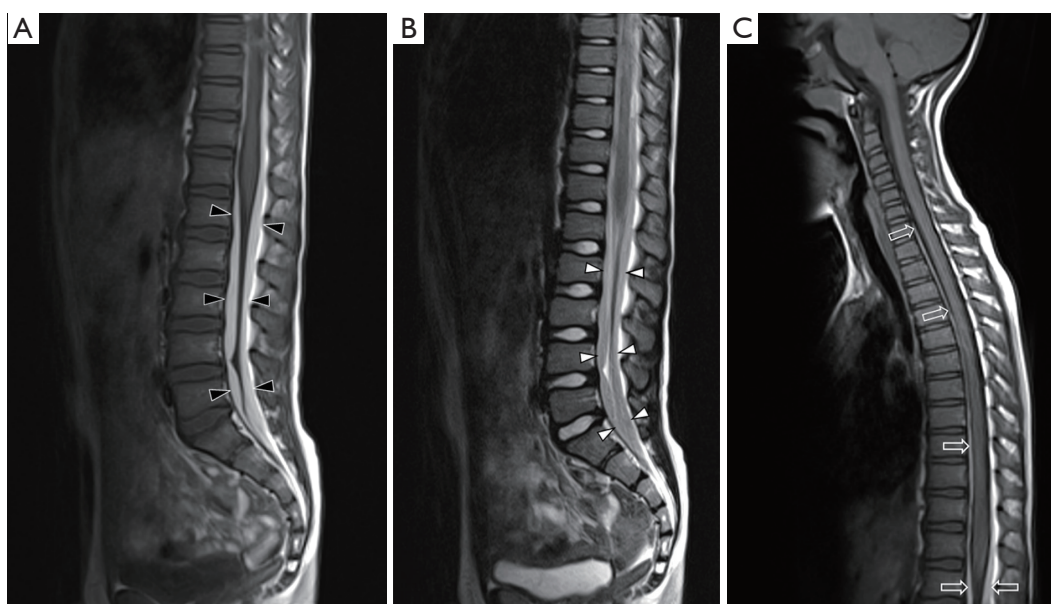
Sagittal (A) T1-weighted and (B) T2-weighted MR sequences of the lumbar spine; (C) sagittal T1-weighted sequence of the cervical and thoracic spine. There are linear collections dorsal and ventral to the lower cord and cauda equina which are hyperintense on T1 (black arrowheads) and intermediate signal on T2 (white arrowheads). The collection extends ventral to the spinal cord up to the level of C7 (open arrows). The location and signal characteristics of these collections raise suspicion for subdural haemorrhage. The T1-hyperintensity of the blood would be consistent with subacute blood (>3 days). There is no significant compression of the lower cord and cauda equina.
